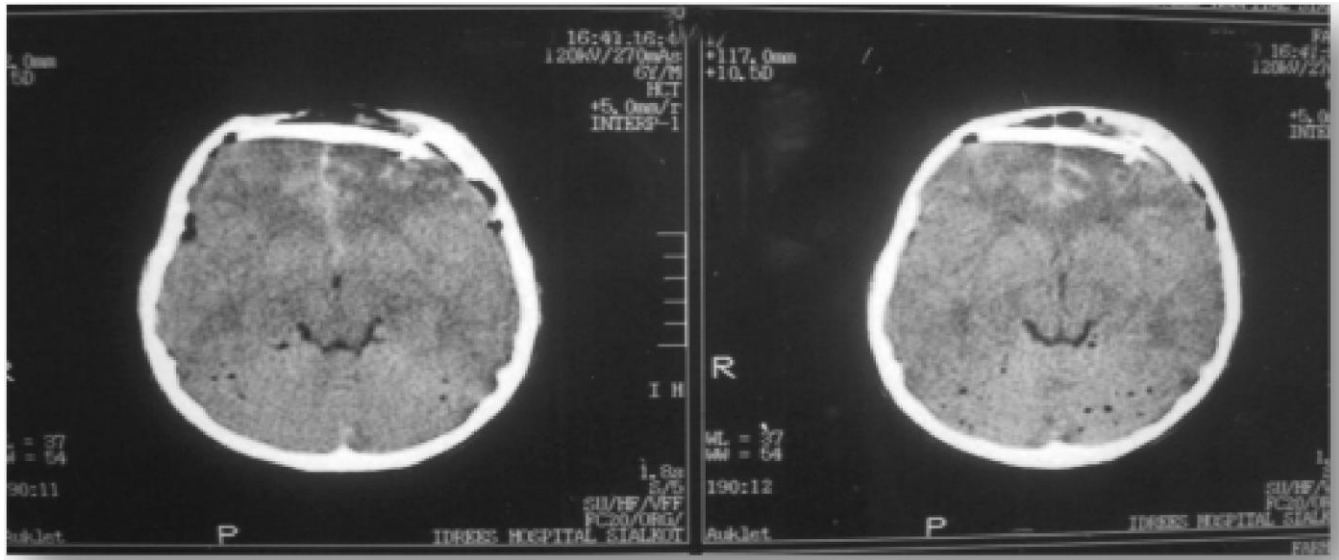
Pre-operative CT scan showing midline depressed fracture.
